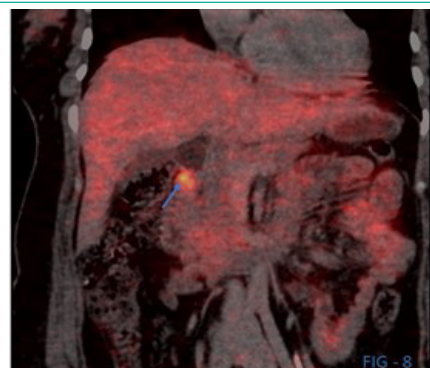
DOTA NOC PET CT (arrow) revealing a somatostatin receptor positive tumor in the pancreatico-duodenal groove.
